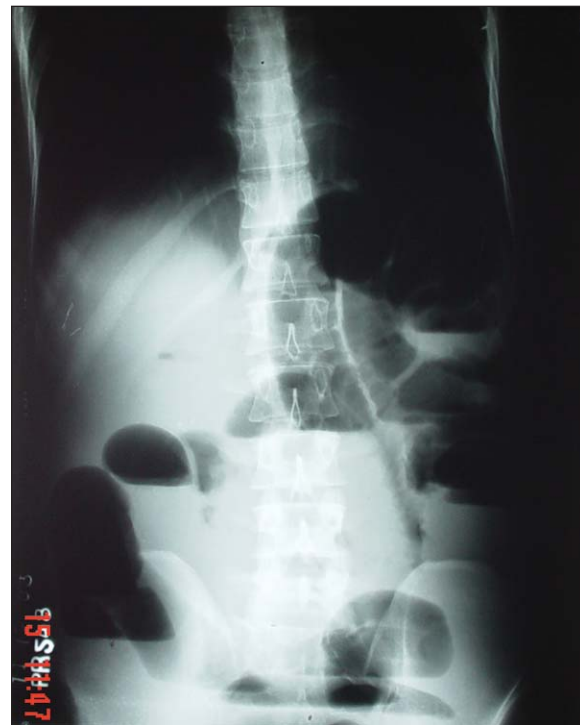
Plain x-ray abdomen in erect posture showing features of small bowel obstruction.
